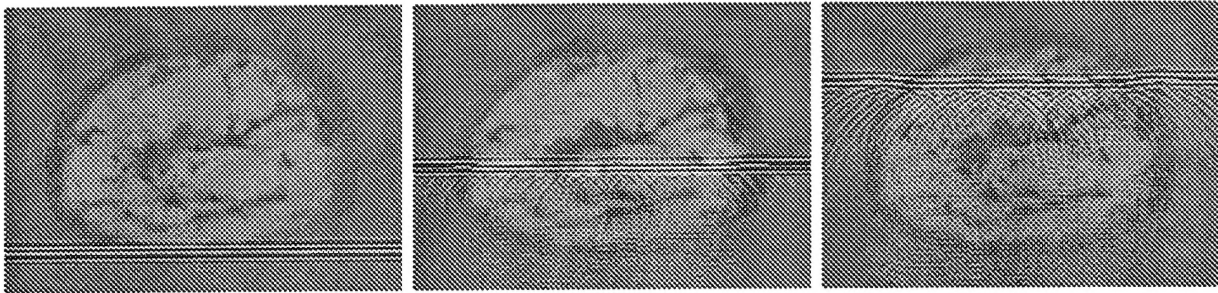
Three frames showing ultrasonic propagation of a 1 MHz pulse through a two-dimensional breast cross-sectional model obtained from the Visible Woman data set. Each panel shows an area of $97 \times 69 \text{ mm}^2$.
